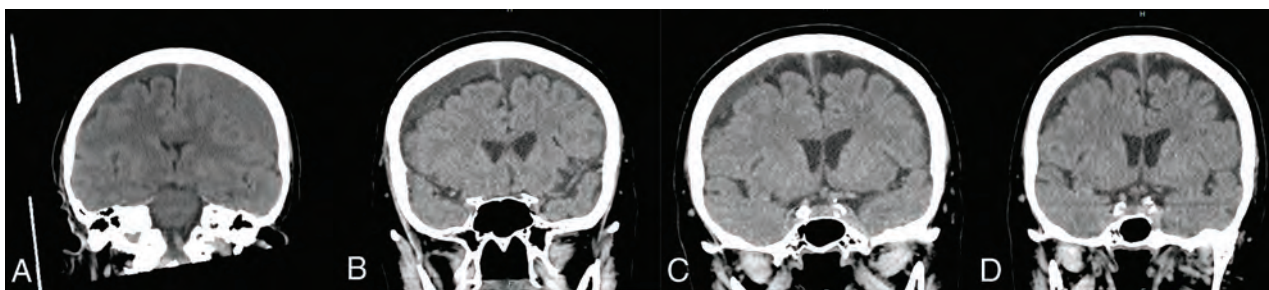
Imaging course of a 75-year-old woman with bilateral cSDHs managed by unilateral burr-hole evacuation followed by bilateral MMA embolization. Noncontrast head CT images were obtained on presentation (A), postoperatively (B), 1 week postembolization (C), and 4 months postembolization (D).
